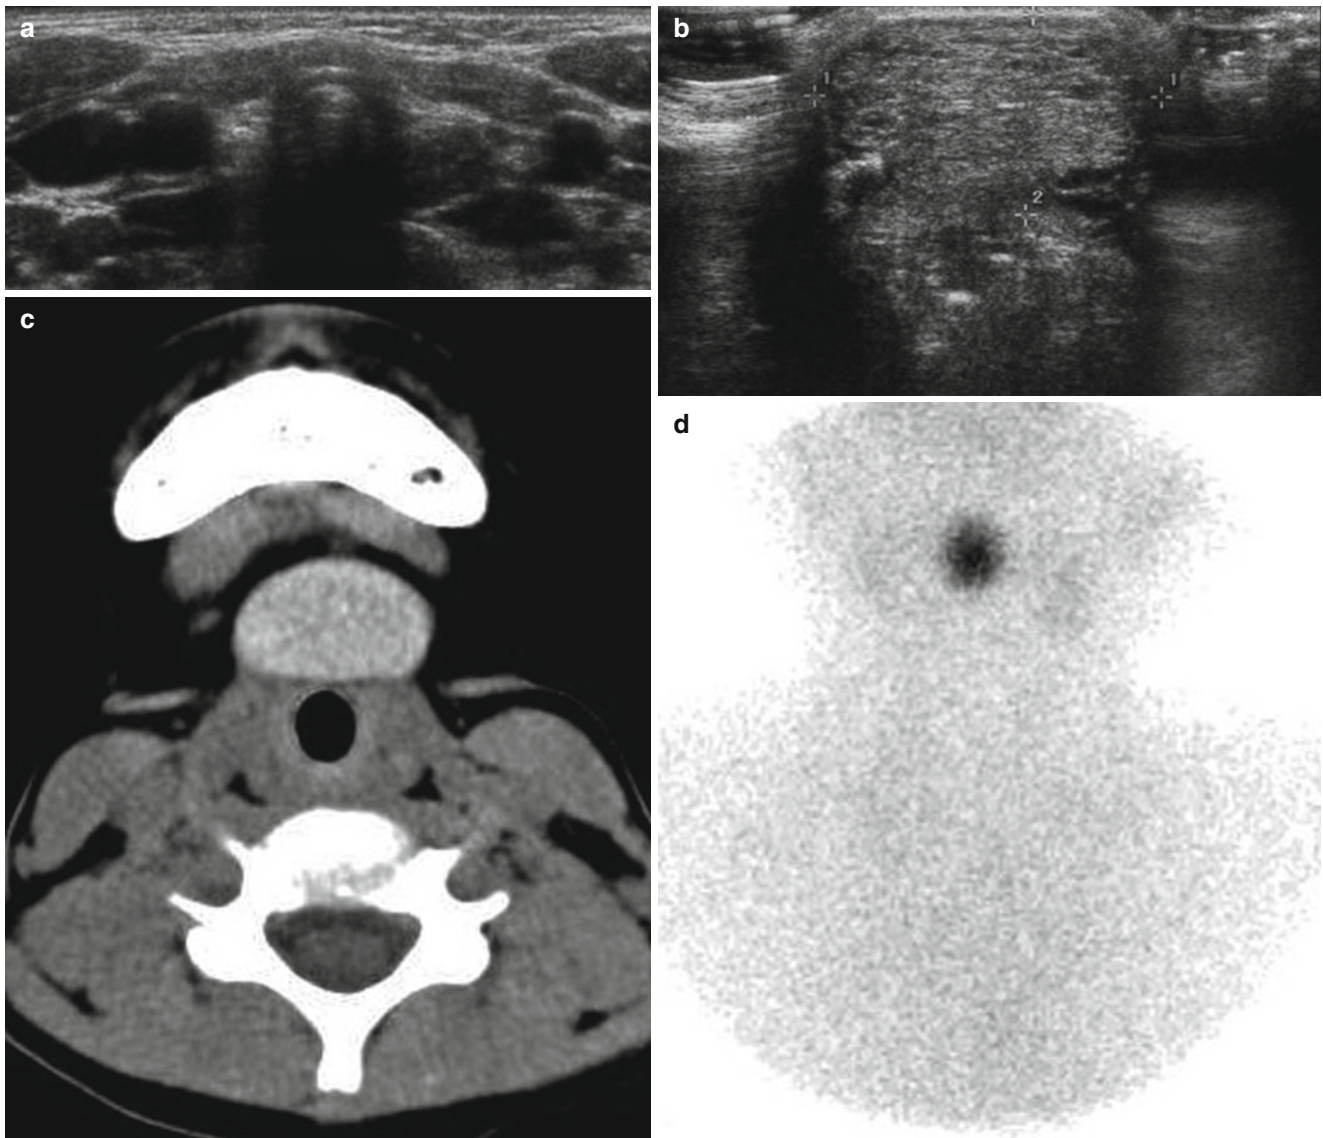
Ectopic thyroid gland in a 7-year-old girl. (a) US shows absence of the thyroid gland at the low neck. (b) US obtained at the level of the hyoid bone shows a heterogeneous echogenic solid mass. (c) Precontrast axial CT scan shows hyperattenuated ectopic thyroid
